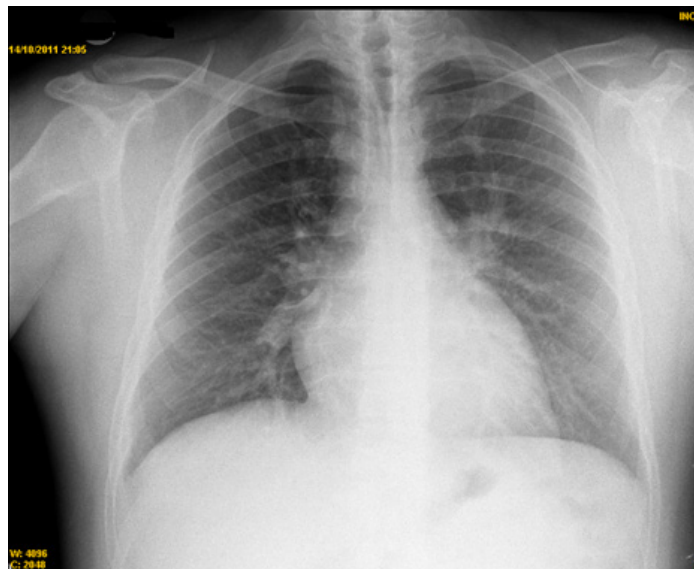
PA Chest X-ray: normal
